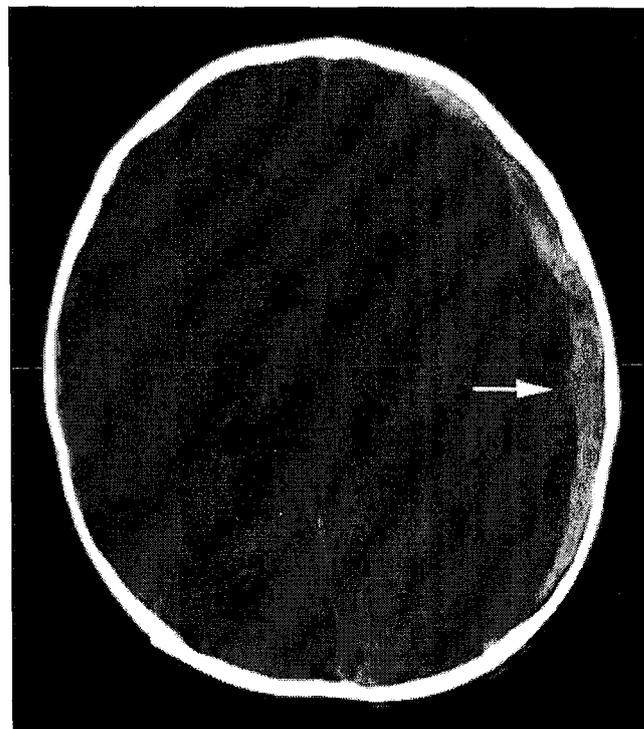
An axial cranial computed tomography image shows an acute mixed low attenuation subdural hematoma (arrow) compressing the left cerebral hemisphere with a resultant 0.7–0.8 cm left to right midline shift.
